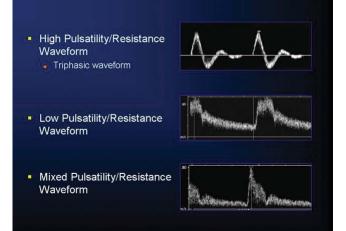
Arterial Doppler waveforms of varying resistance. Arterial resistance pertains to the characteristics of the arterial bed itself. Since the arterial bed determines the shape of the waveform in the afferent vessel(s), arterial waveforms themselves are often described as high resistance or low resistance. Others prefer to use the terms high and low pulsatility. In general, high resistance waveforms are also high pulsatility waveforms and low resistance waveforms are low pulsatility waveforms^{1,2,3}.
